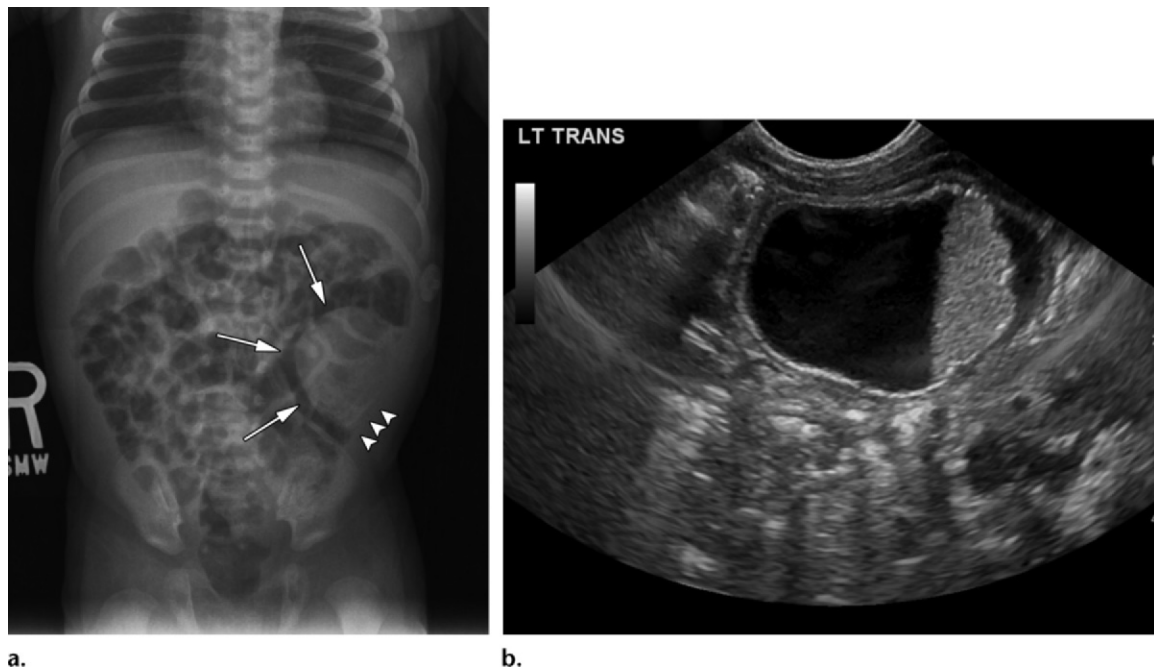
In utero ovarian torsion in an 11-day-old infant who presented with fussiness. (a) Frontal abdominal radiograph shows a round soft-tissue mass (arrows) in the lower left region of the abdomen, superior to the pelvis. Calcification (arrowheads) is seen at the periphery of the mass. (b) Transverse US image shows a cystic mass with a fluid-debris level, in the left abdominal region. A double wall sign—that is, an echogenic inner wall and hypoechoic outer wall—is present. The highly echogenic inner wall suggests calcification, which was confirmed on the radiograph.
